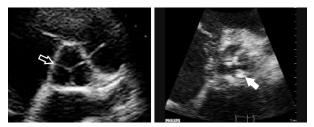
Parasternal short-axis view on a transthoracic echocardiogram showing a normal appearing aortic valve with clearly defined leaflets (open arrow) and calcification in the margins of aortic valve leaflets with lack of crisp definition (solid arrow).
